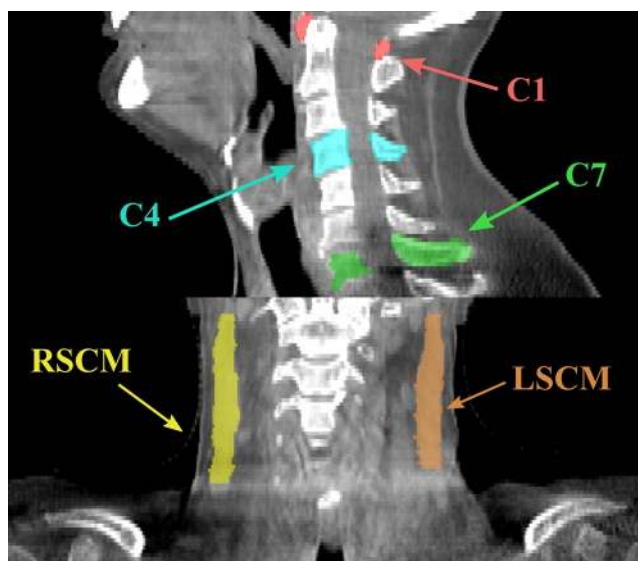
Features identified on the CT and CBCT images for the geometric evaluation: bony anatomy (vertebrae C1, C4, and C7) and left and right sternocleidomastoid muscles (LSCM and RSCM).
